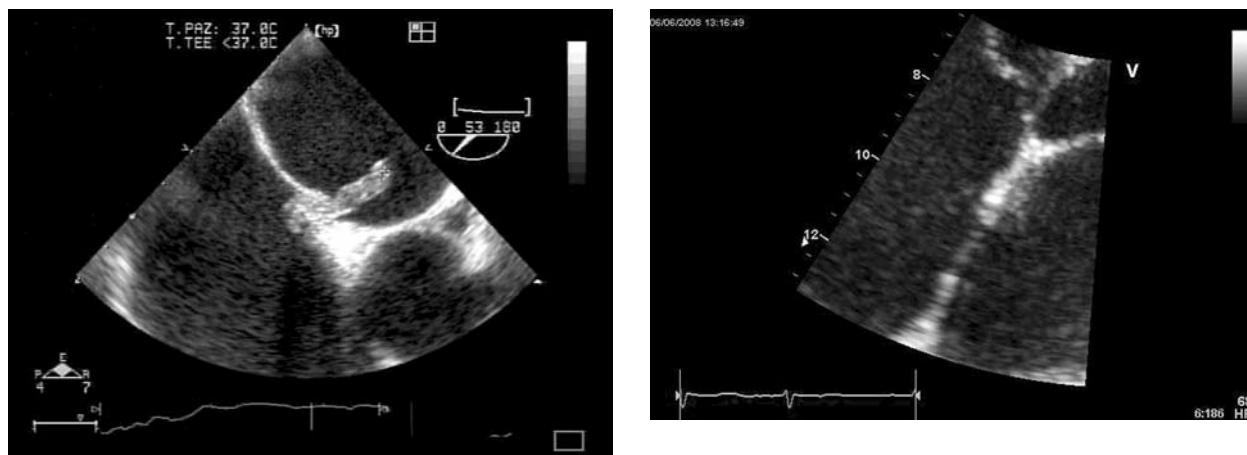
Thrombus straddling the patent foramen ovale, transesophageal echocardiography
